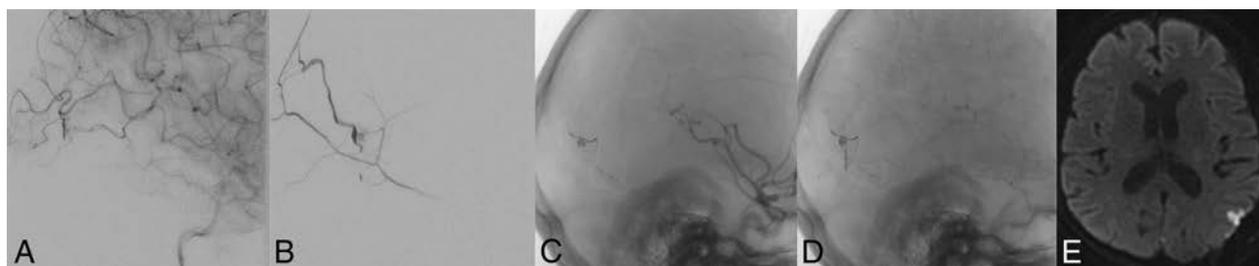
Postsurgical seizure and small cortical infarction after surgical ligation of a residual DAVF. A middle-aged woman status 1 year post temporal lobe hemorrhage underwent endovascular therapy for a Borden-Shucart grade III DAVF supplied principally by the left middle meningeal artery (B) and secondarily by pial branches of the left MCA (A), with drainage directly to a cortical vein. Onyx embolization eliminated the middle meningeal artery dural supply (C), but late-phase angiographic images demonstrated persistent MCA pial supply (D). Three days following a craniotomy for successful ligation of the residual DAVF, the patient had a seizure. MR imaging at that time demonstrates a small cortical infarction (E).
